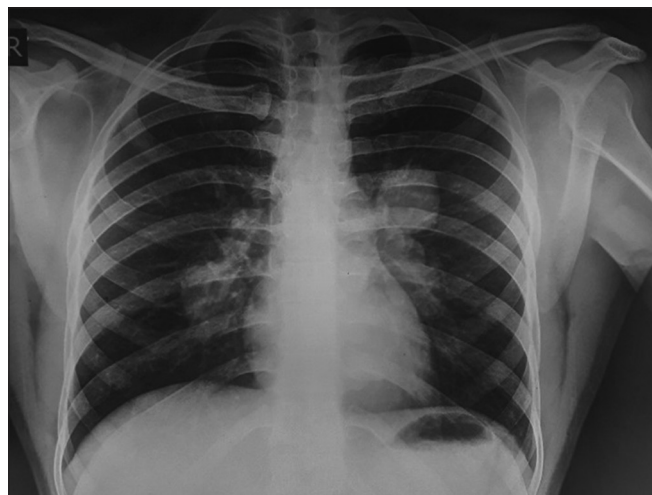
Chest X-ray PA view: rounded opacity in the left upper lobe. PA: Pulmonary artery
